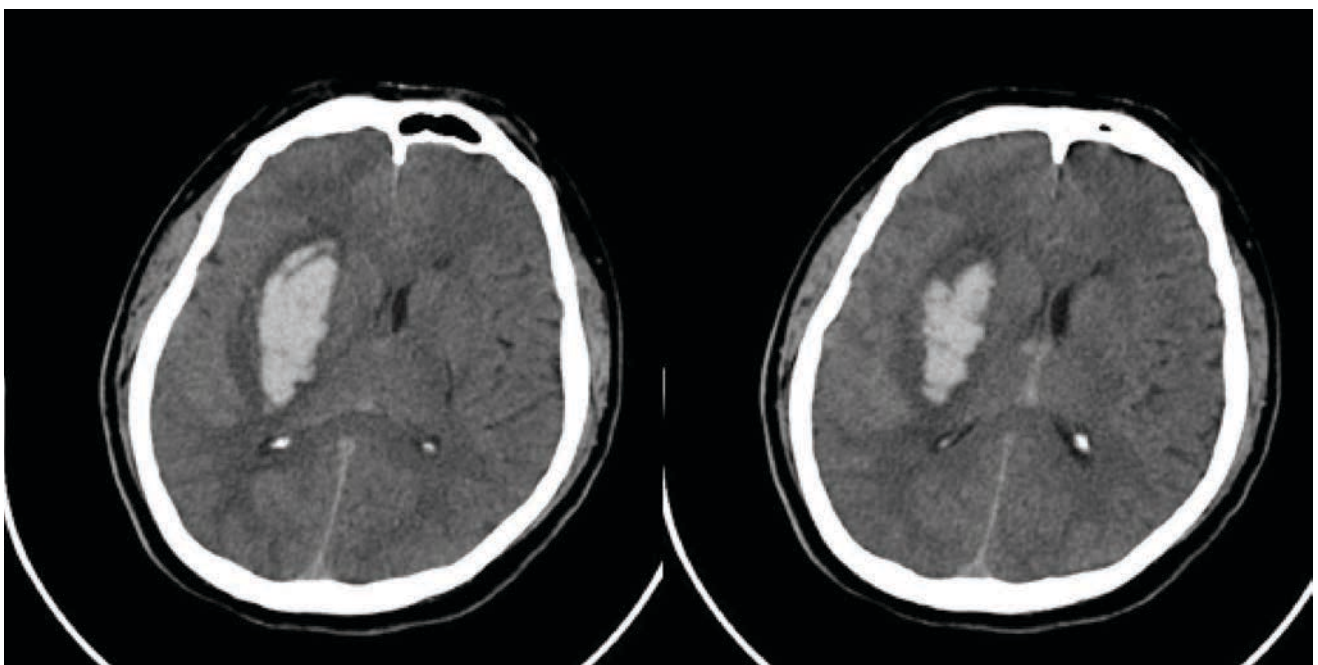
The brain CT showed right thalamic hemorrhage
